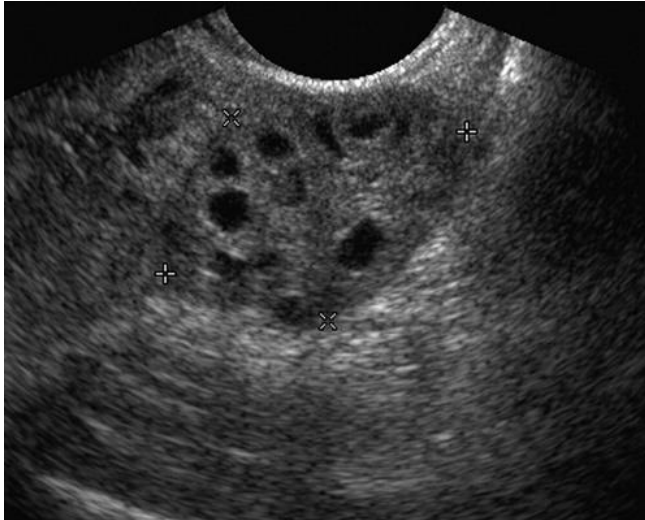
Sonography of a normal ovary with randomly arranged follicles
